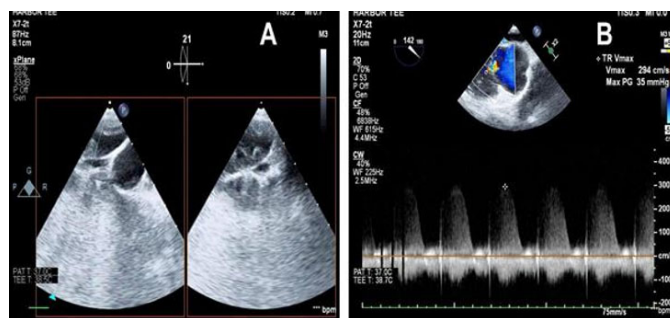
(A) A transesophageal echocardiogram (TEE) shows venous thromboembolism in the right main pulmonary artery (PA), along with a normal left PA. (B) A modified bicaval view shows tricuspid regurgitation (TR) with a maximum velocity of 294 cm/s and a gradient of 35 mmHg.
